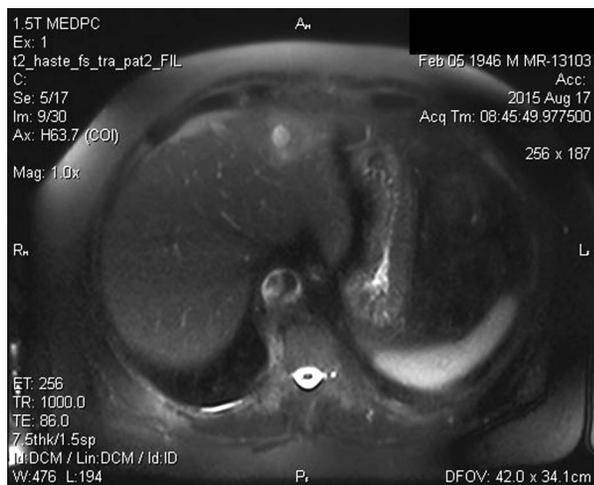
MRI scan: Axial T2 weighted haste image. A well demarcated cystic lesion surrounded by inhomogeneous liver tissue in the left liver lobe
